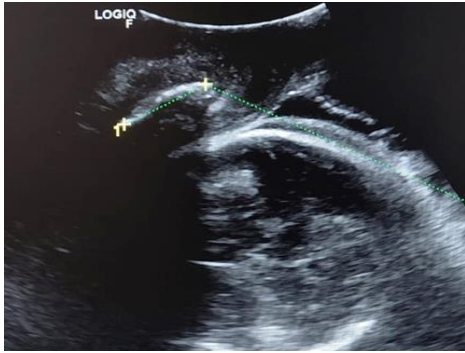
Transperineal Ultrasound. Measurement of Angle of Progression
